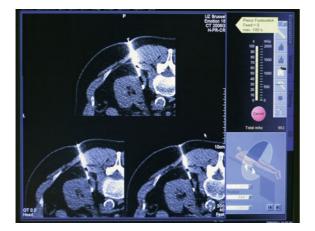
Multiple-image CT fluoroscopy
